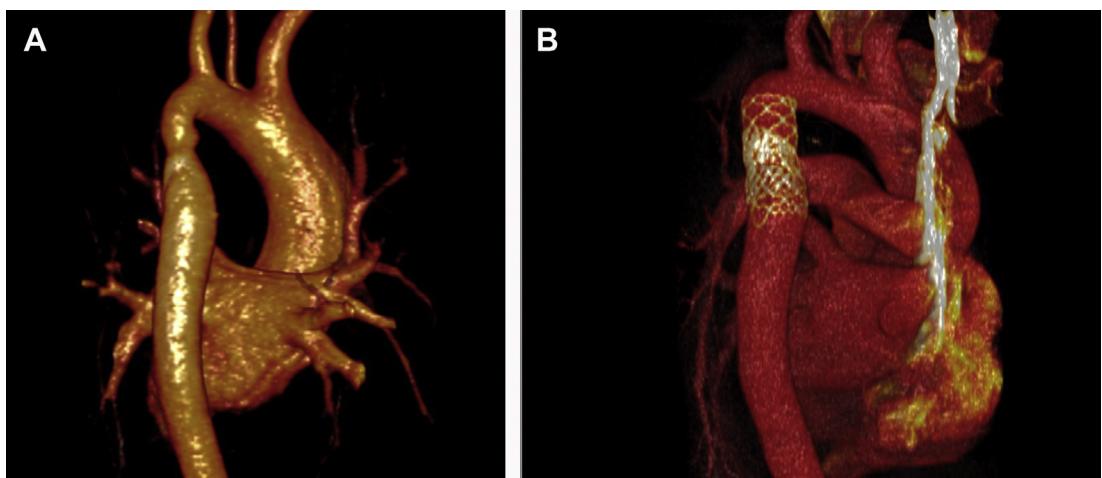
(A) MRI angiography with 3-dimensional volume rendering, right posterior projection, demonstrating severe recurrent coarctation in a patient that had undergone surgical end-to-end repair in infancy. (B) Computed tomography angiography, similar projection, after covered Cheatham platinum stent placement and EV-3 Mega LD open cell uncovered stent placement with complete resolution of aortic narrowing.
